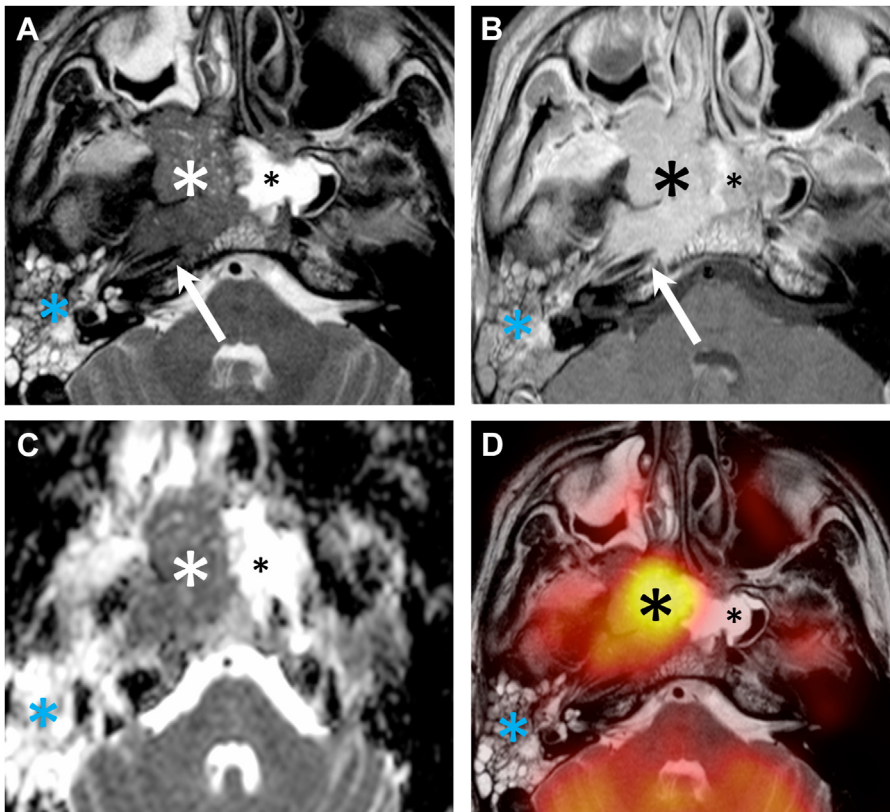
Characteristic PET/DWIMR imaging features of an advanced primary nasopharyngeal cancer. (A) T2W image. (B) Contrast-enhanced T1W image. (C) ADC map from DWI. (D) Fused PET and T2W image. Infiltrating tumor (large asterisks) with an intermediate signal intensity on T2W images, enhancement after IV administration of contrast-material and restricted diffusion ($ADC = 0.86 \times 10^{-3} \text{ mm}^2/\text{s}$). High FDG uptake ($SUV_{max} = 11$). Skull base invasion reaching the right carotid canal (arrows). Blue asterisks indicate fluid retention in the right mastoid air cells. Small asterisks indicate fluid retention in the sphenoid sinus.
